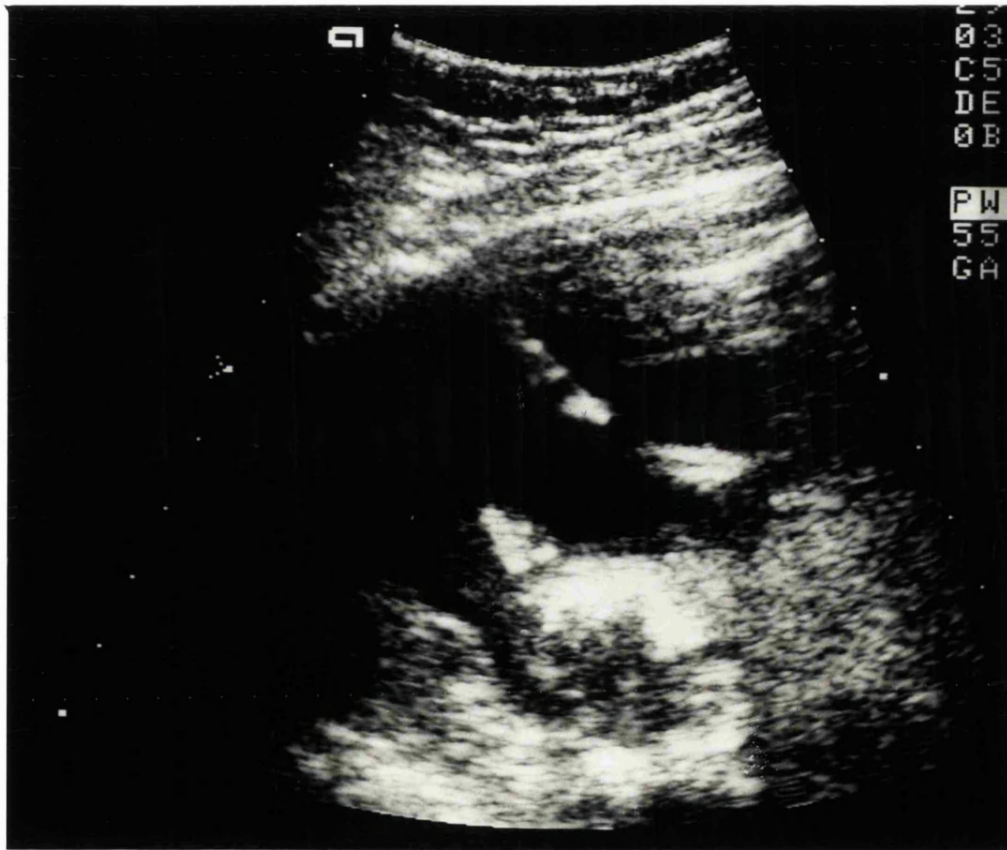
Ultrasound picture of needle free in pool of liquor during amniocentesis.
